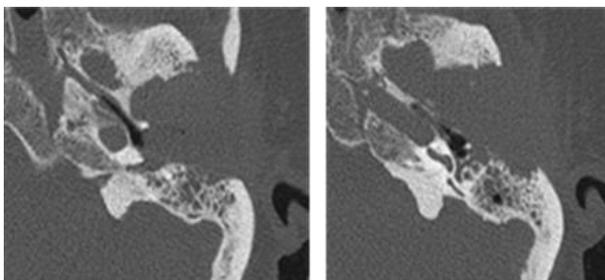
(a) axial cut CT scan of the left temporal showing an adenocarcinoma-like appearance of the left external auditory canal significantly eroding the skull base in the TMJ and mastoid region. (b) axial cut temporal CT scan similar to a lower level shows invasion into the middle ear
